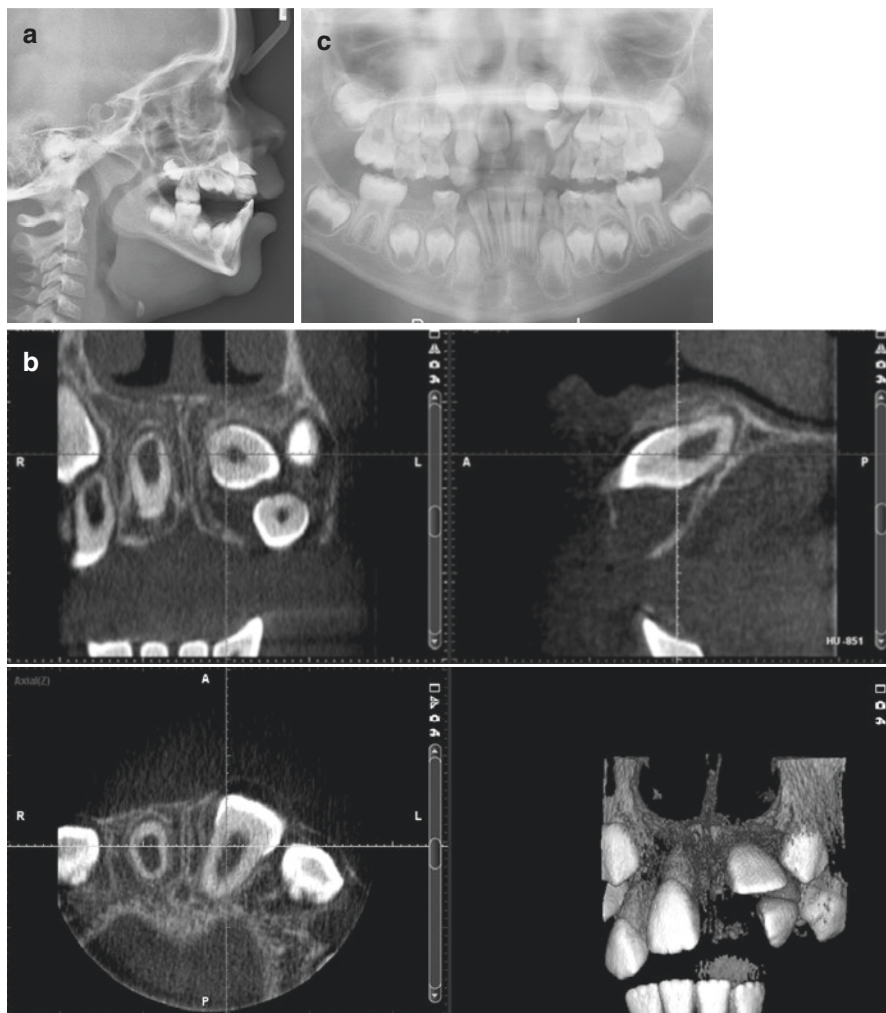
Pretreatment imaging for the unerupted maxillary incisor (shown in Fig. 7.5 following exposure and bonding). (a) Cephalometric lateral skull radiograph. (b) CBCT. (c) Panoramic radiograph
